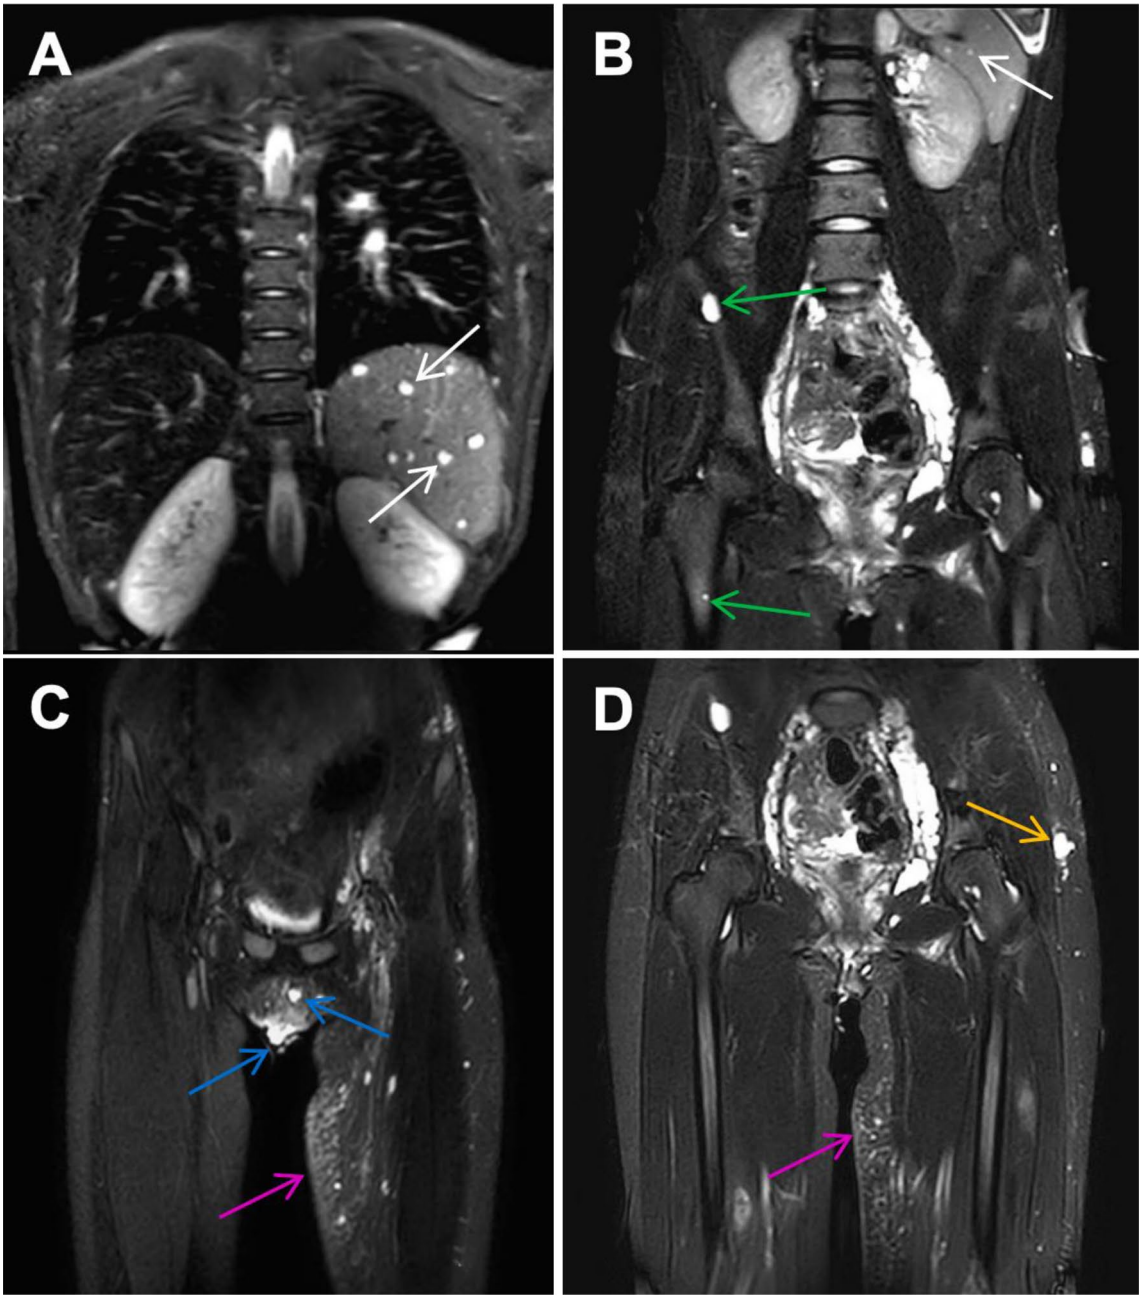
MRI images. A-D, MRI coronal view showed multiple lymphangiomas of the spleen(white arrow), right ilium and femur(green arrows), labia(blue arrows), and the left pelvic subcutaneous(orange arrows); C-D, lymphoedema of the left thighs can be seen(pink arrows)
